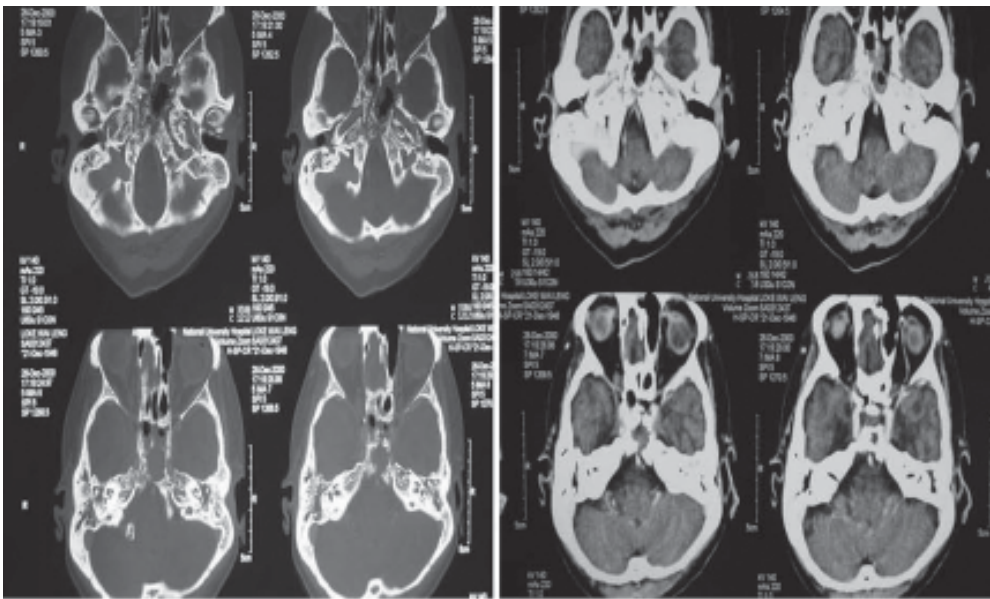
CT scan temporal bone with intact cochlear and cochlear nerves.
